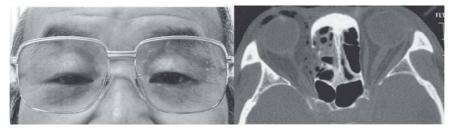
A 62-year-old man who wore metal frame glasses hit the frame of the glasses on a shelf. He felt swelling around his right orbital region following nose blowing. A CT scan revealed a right orbital medial wall fracture and emphysema in the orbital soft tissue. No fractures were revealed on the nasal bone or right orbital rim.
